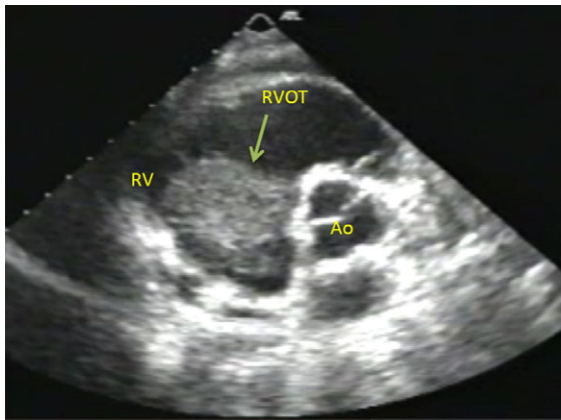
Parasternal short-axis view showing the aorta (Ao), the right ventricular outflow tract (RVOT), and the right ventricle (RV). There is a large irregular mass (arrow) is seen filling the right ventricular cavity.
